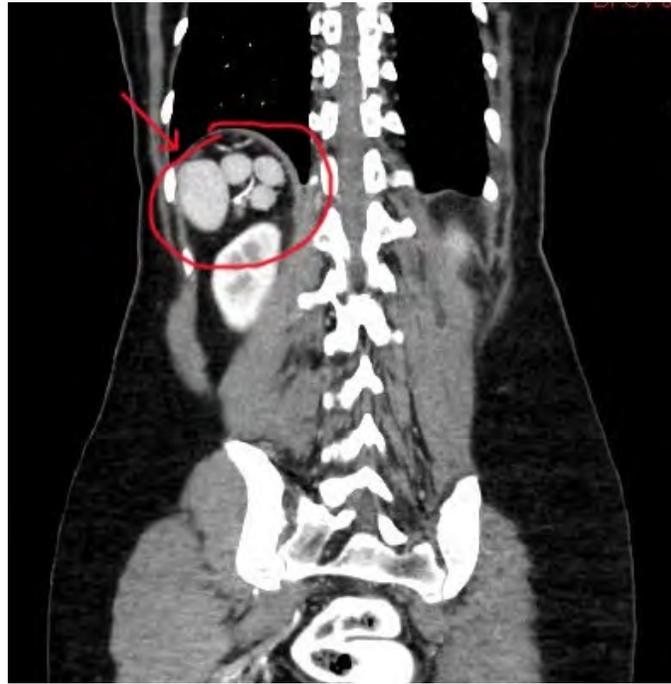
Polysplenia: Multiple, right-sided spleens on abdominal CT scan (circle).
